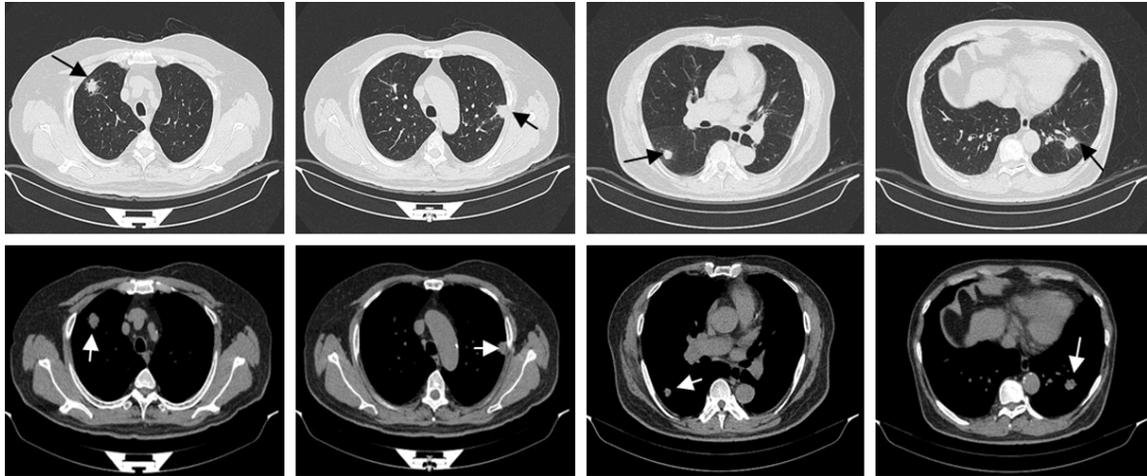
Initial chest computed tomography scans in the pulmonary window (*upper row*) and mediastinal window (*lower row*) showed multiple and bilateral lung nodules, particularly in the subpleural area. Some nodules had short burrs.
